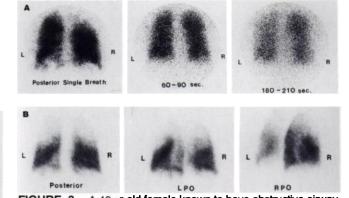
A 40-yr-old female known to have obstructive airway disease was referred for a V/Q scan to rule out pulmonary emboli after sudden worsening of shortness of breath. The patient had a history of smoking (30 pack-yr). Chest x-ray showed no infiltrates. The ventilation study (A) reveals significant retention of xenon in both lungs. The pattern of ventilation on single-breath image partly matches and partly mismatches the perfusion abnormalities on posterior projection of the perfusion study (B). On the other hand, washout images show diffuse retention of xenon involving areas with and without perfusion abnormalities. Pulmonary angiogram subsequently performed shows multiple pulmonary emboli.
